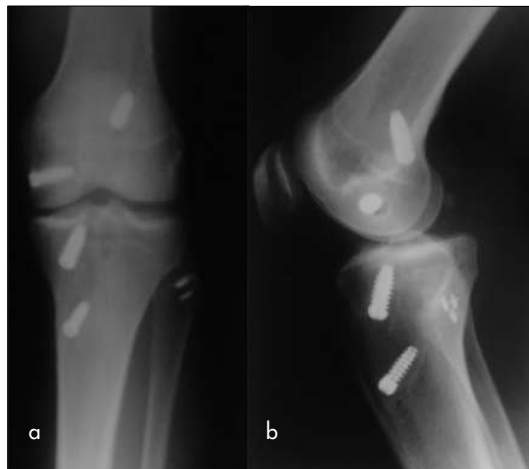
a. Anteroposterior and (b) lateral radiographs showing screw fixation after anterior and posterior cruciate ligament reconstruction and suture anchors in the fibular head from an acute repair of the posterolateral corner.
